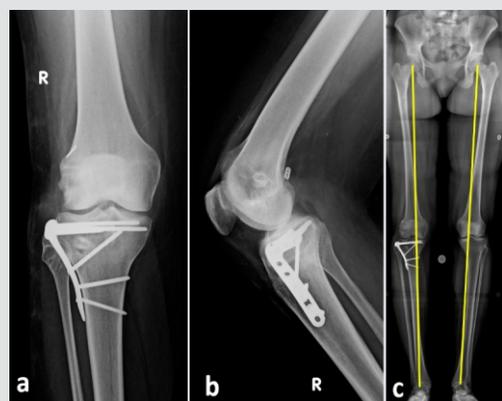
Post-operative radiographs after the first stage surgery showing the fixation of the intra-focal osteotomy in AP (a) and lateral (b) views. The AP scanogram showing complete healing of the osteotomy showing no change in the varus alignment (c).
